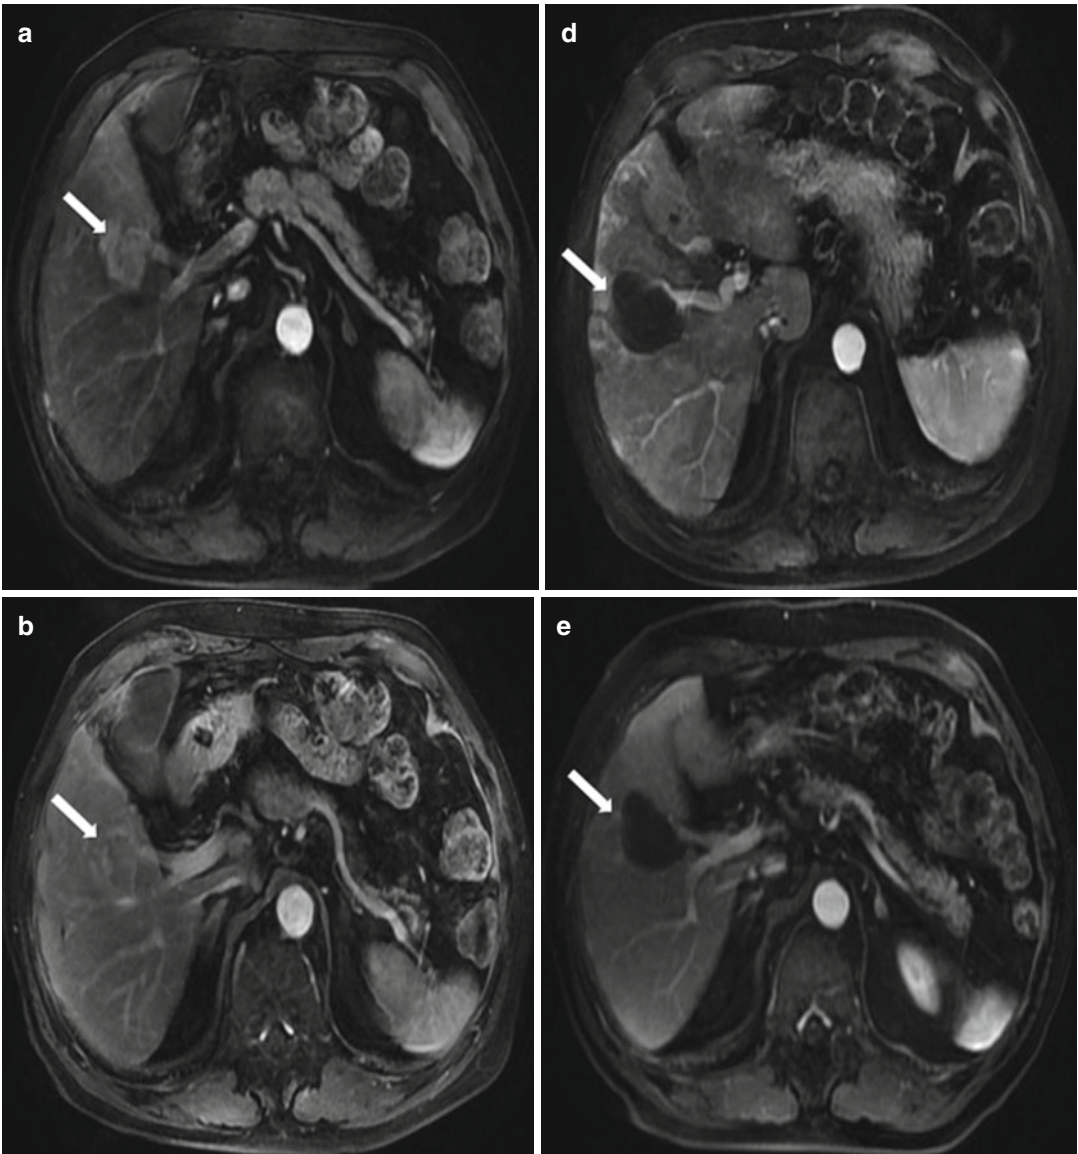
Microwave ablation (MWA) in an 85-year-old man with liver tumor (3.2×3.0 cm) adjacent to the hepatic hilum. (a) Contrast-enhanced magnetic resonance imaging (MRI) before MWA showed the tumor with high enhancement in arterial phase (arrow). (b) Contrast-enhanced MRI before MWA showed the tumor with low enhancement in portal venous phase (arrow). (c) Coronal MRI showed the lesion adjacent to the hepatic hilum
